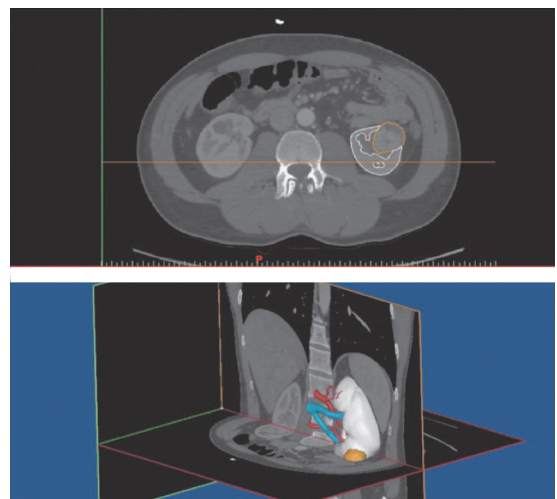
CT segmentation and 3D rendering to realize HA3D™ reconstruction.
